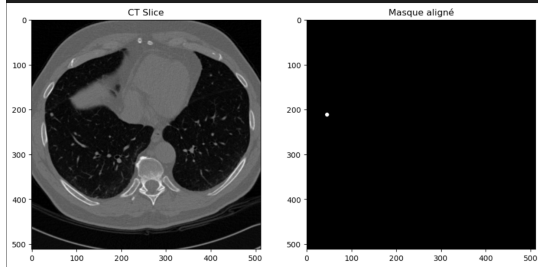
CT Slice and Corresponding Aligned Mask from U-Net Segmentation
